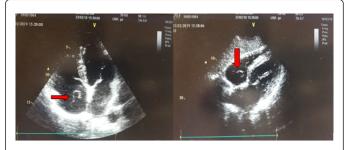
Image of transthoracic echocardiography showing the highly developed Chiari network (arrow).
